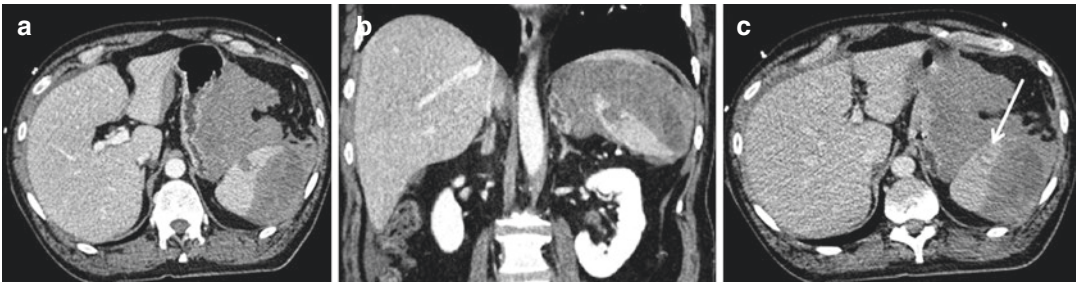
Grade 4a: Subcapsular and parenchymal replenished hematoma associated with “large” hemoperitoneum. CT scan: the venous phase (a, b) allows to
